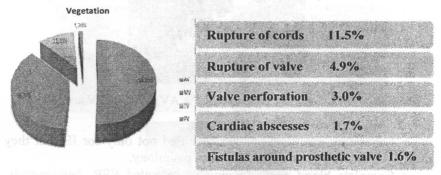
Echocardiography changes in patients with IE Echocardiography images of patients from the study.
